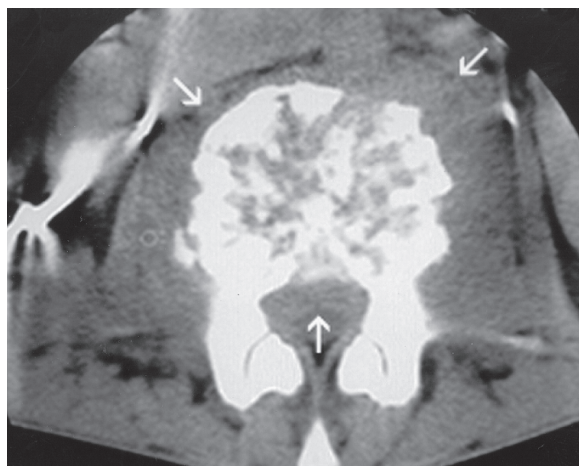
An axial CT scan at the corpus of L-2 shows diffuse destruction and reactive sclerosis areas. There is also paraspinal abscess formation with semi-solid density (21 HU), extending to epidural space (arrows).
